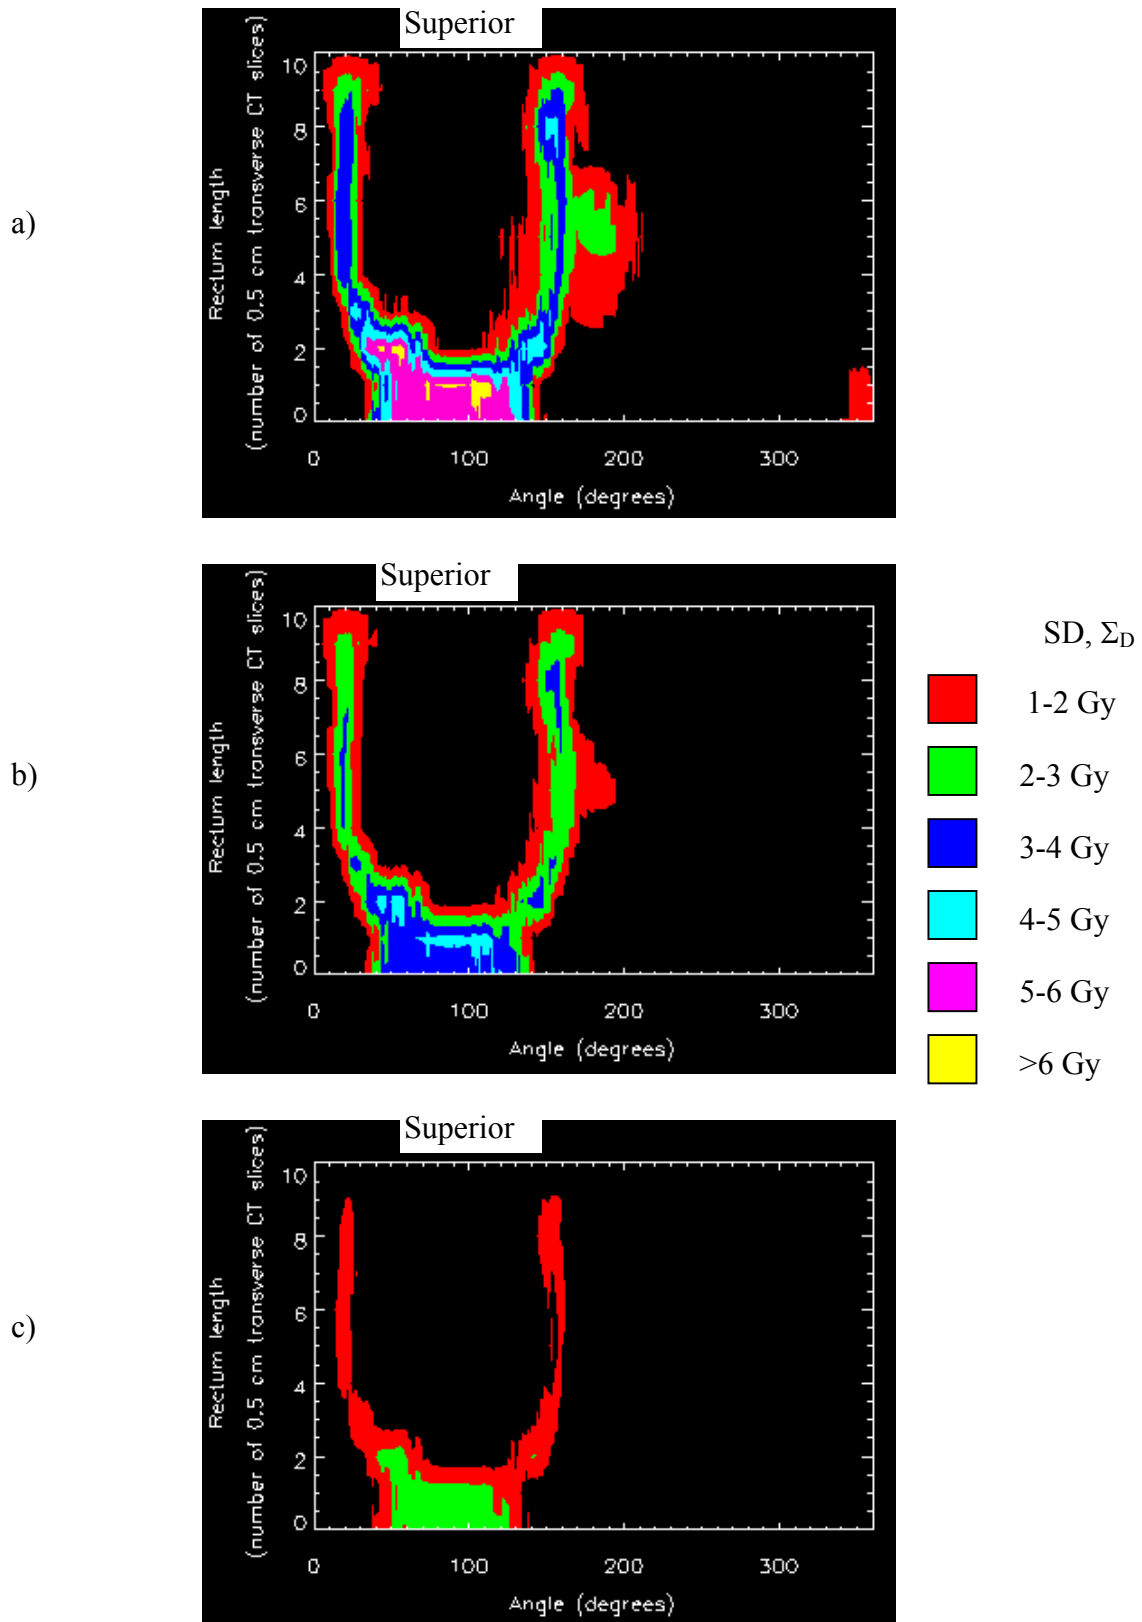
The standard deviation in rectal wall dose calculated with 10 mm margin and a) one pretreatment CT scan with, b) two pretreatment CT scans, and c) infinite pretreatment CT scans. Orientation: Left=0°; Anterior=90°.
